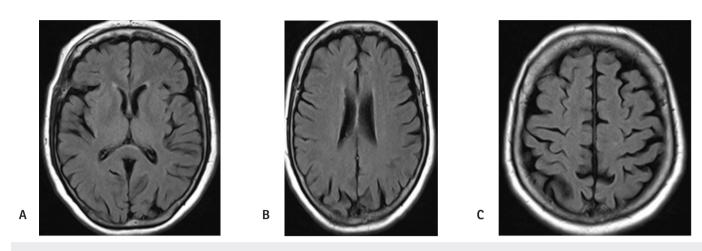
A-C) Magnetic resonance imaging (MRI) of the brain, axial fluid-attenuated inversion recover FLAIR sequences at MRI cerebral white matter lesions, MRI white matter lesions in the splenium of the corpus callosum and generalized brain atrophy
